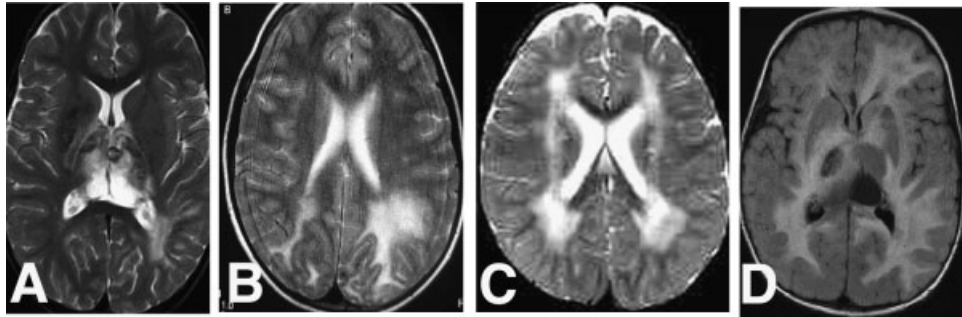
MRI scans demonstrating variable and patchy signal abnormality in the thalamus, internal capsule, and white matter. A cystic mass is present in the right thalamus and another in the splenium of the corpus callosum of Patient 9 (D). [A: Patient 2 at 3 years; B: Patient 3 at 12 years; C: Patient 7 at 3 years; D: Patient 9 at 9 months].
